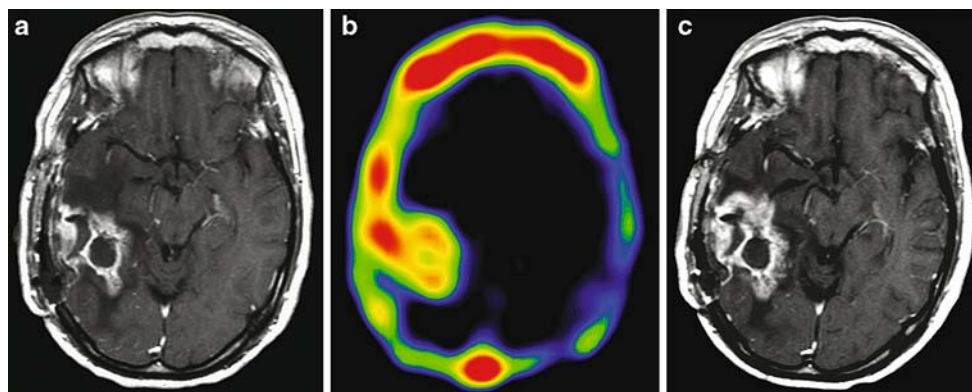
Neuroimaging studies showing recurrent tumor activity. (a) T1-weighted postcontrast axial MRI obtained 3 months following resection of the primary tumor showed enhancement around the resection cavity with edema and midline shift. (b) Proliferation imaging with 3-deoxy-3[18F]fluoro-L-thymidine positron emission tomography (FLT-PET) conducted 2 weeks
